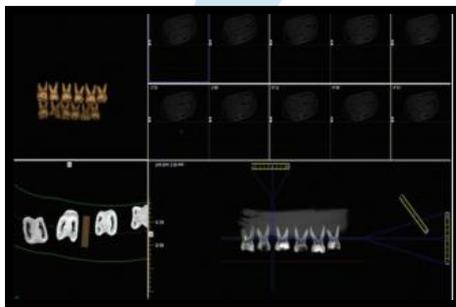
Cone beam computerized tomography image showing the measurement for diameter of root canals
